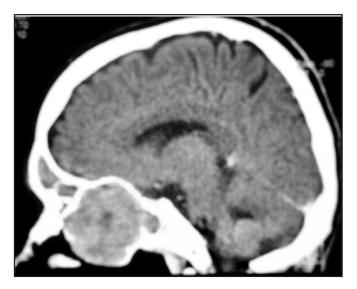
Pre-op CT Scan (Sagittal view) showing the mass extending into the sphenoid cavity. The skull base is intact with no intracranial extension.
